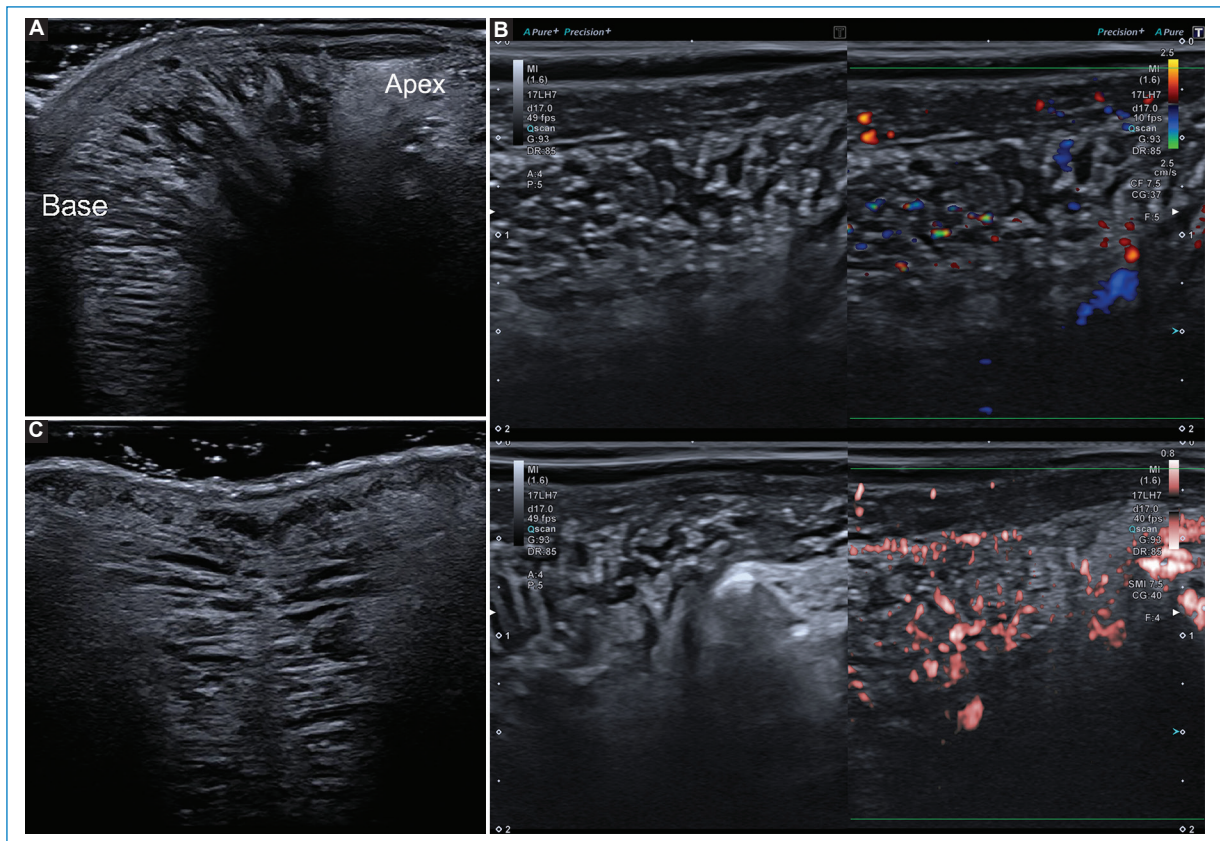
Evaluation with a 24 MHz linear transducer. In this patient, the entire tongue was visualized almost to its base (A), the vascularization of the superficial planes of the tongue was evaluated with Doppler color mode and Superb Micro-vascular Imaging (SMI) (B), and a transverse slice with the transducer is shown (C).
